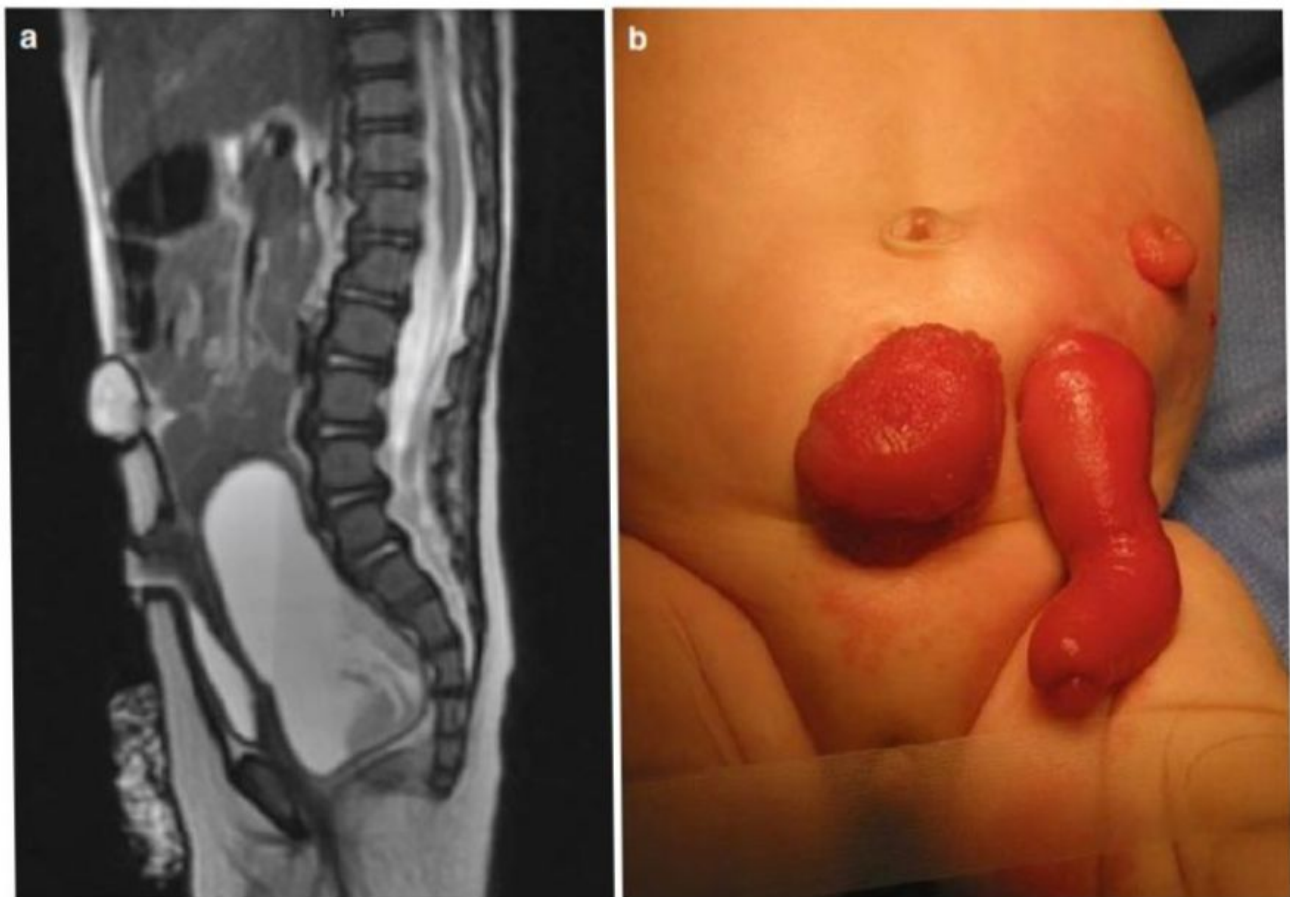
(a) Picture of a baby with a cloaca, who underwent a colostomy and a non-indicated vesicostomy. The vesicostomy is prolapsed because it was not done correctly and the hydrocolpos remained tense and undrained. (b) MRI showing a sagittal view, the vesicostomy and the undrained hydrocolpos
